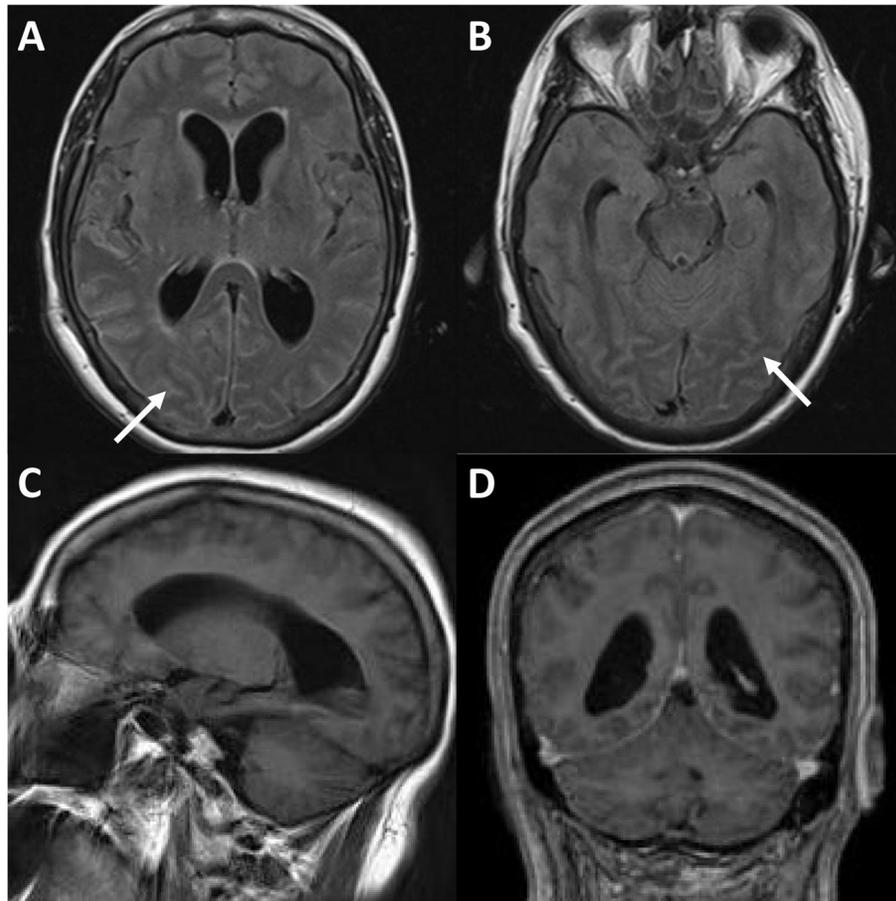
Magnetic Resonance Imaging of the brain demonstrates hydrocephalus and abnormal signal in subarachnoid space
